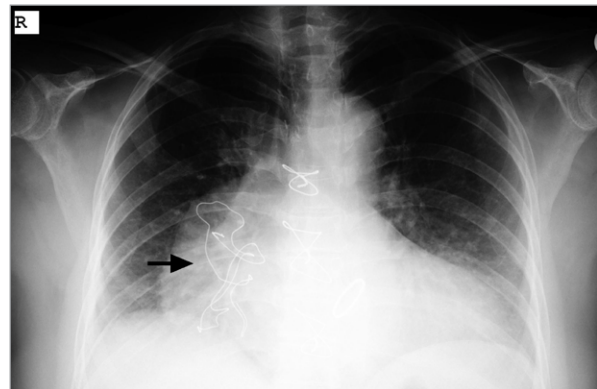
Patient 2. Radiograph shows a radiopaque whorl lateral to the aorta.
